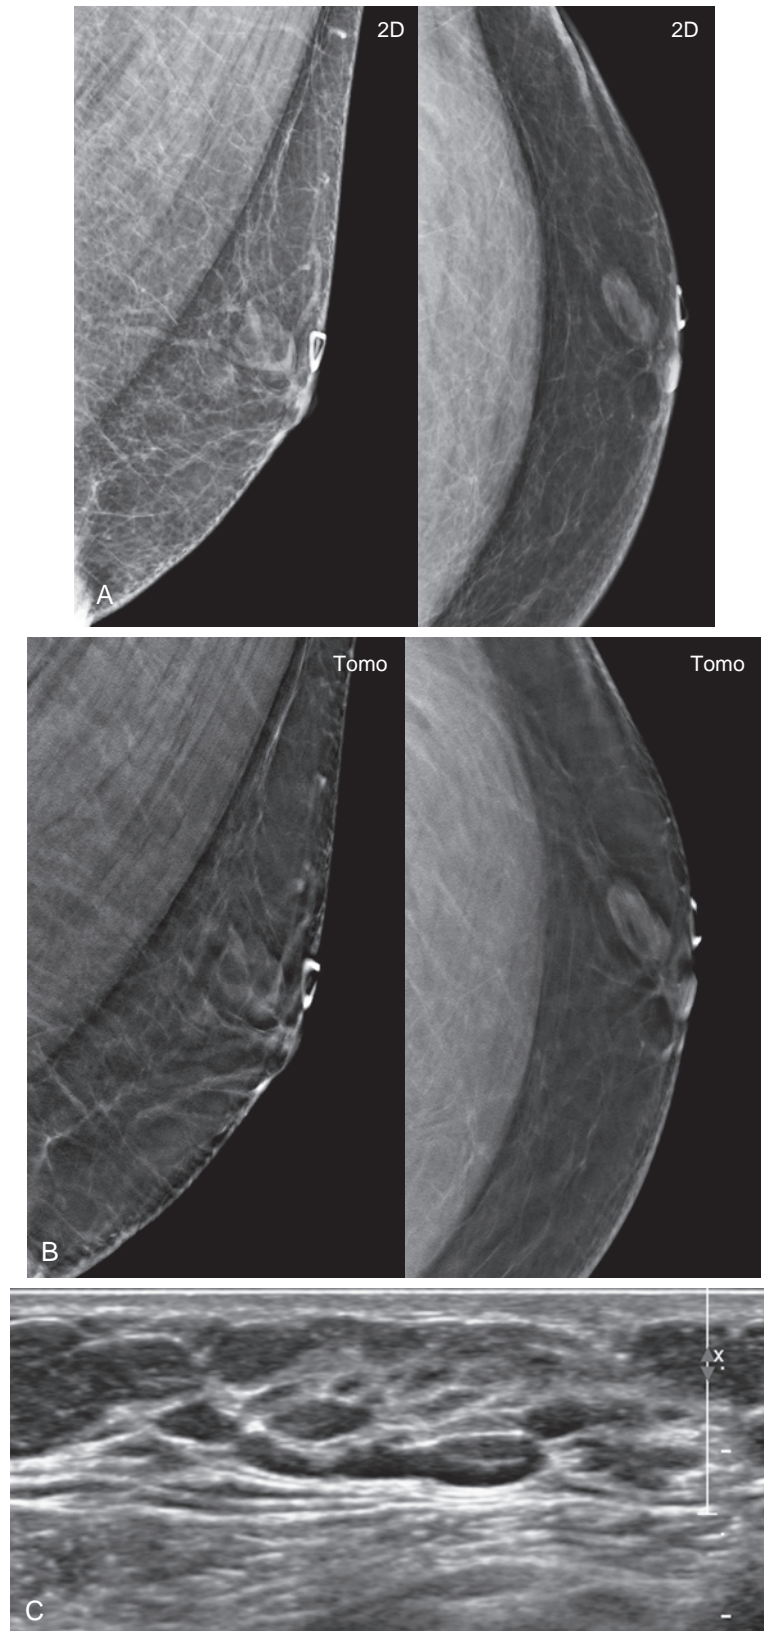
Pseudoangiomatous stromal hyperplasia. (A) A 59-year-old man presents with a recurrent palpable lump in the periareolar area at the 1-o'clock position of the left breast. He has a history of previous excision of a mass in the same location, reported as benign. (B) An oval, fat-containing mass is seen in the subareolar region on the tomosynthesis views, correlating to the palpable abnormality. (C) Ultrasound shows an oval, mixed echogenicity lesion. Biopsy revealed pseudoangiomatous stromal hyperplasia.
